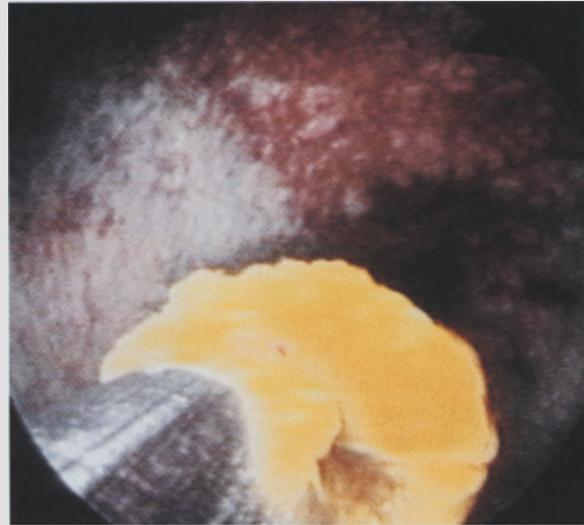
Ultrasonic stone fragmentation inside gallbladder
